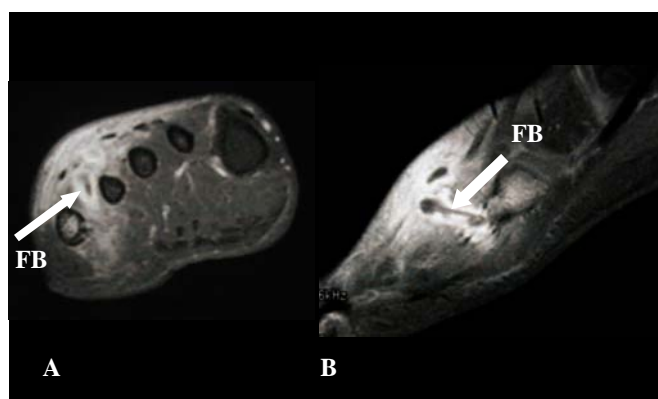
Teenage boy with retained phoenix palm. The negative ultrasound 1 year prior was probably due to poor access and the FB being end on. (A) coronal and (B) sagittal T1 MR of forefoot demonstrates the FB.
